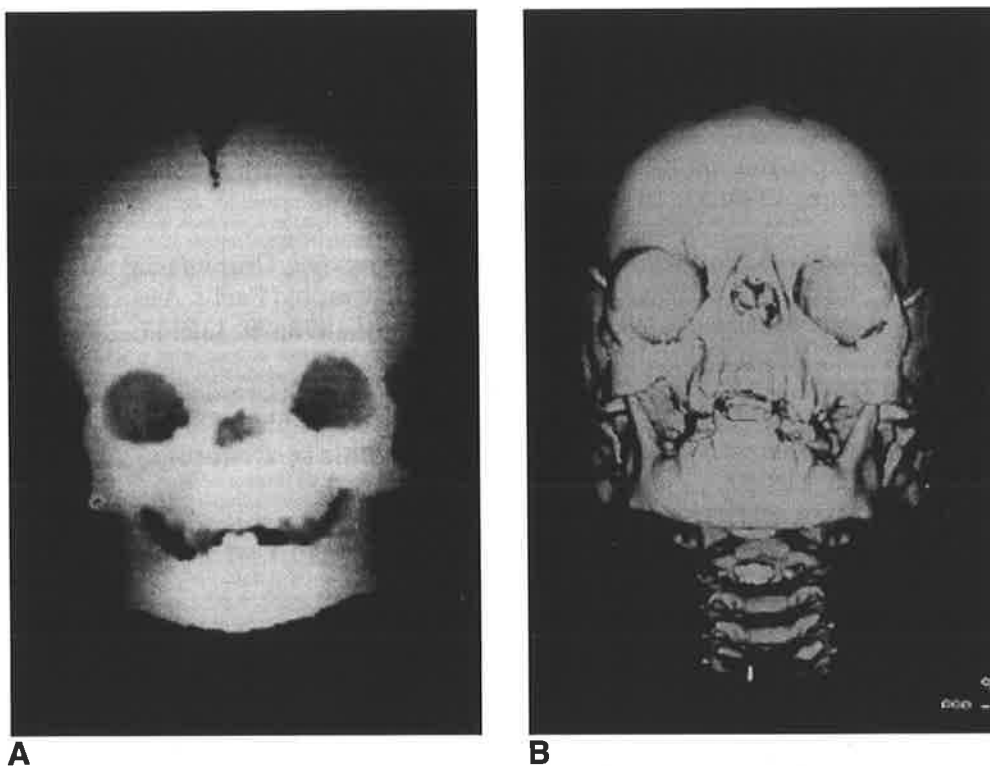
A. B. (Case 6). ID CT Scans before insertion of tissue expanders A, and after two years of expansion B. Note the increase in size of the orbits. In this patient, the expanders were inserted subperiosteally and caused thinning and upward displacement of the orbital roofs, although this cannot be seen in these views.
